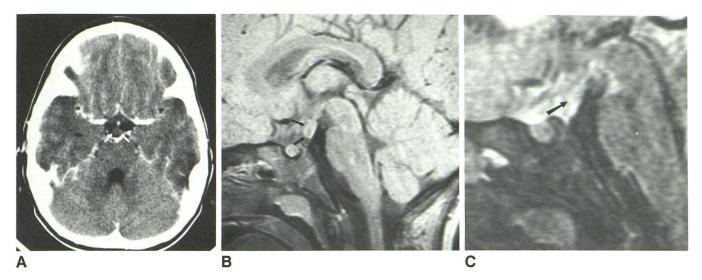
Case 1. A, CT scan shows isointense, nonenhancing mass (arrows) lying between pituitary stalk and basilar artery. B, On T1-weighted MR image, mass appears isodense (arrows). Its attachment to tuber cinereum and pedunculation into interpeduncular cistern is optimally demonstrated. C, On T2-weighted MR image, there is difficulty in identifying the mass because of surrounding hyperintense CSF (arrow).
